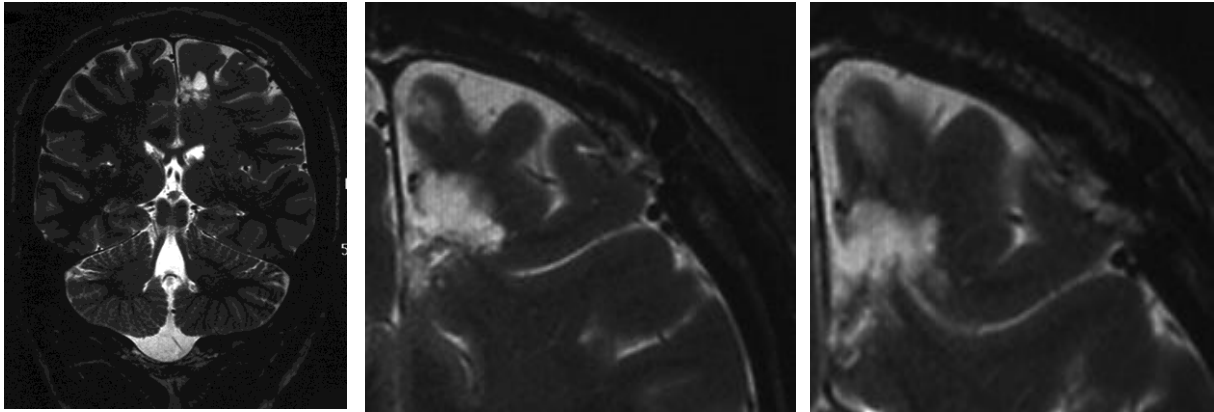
Postoperative axial MRI and magnified images showing dural structures
